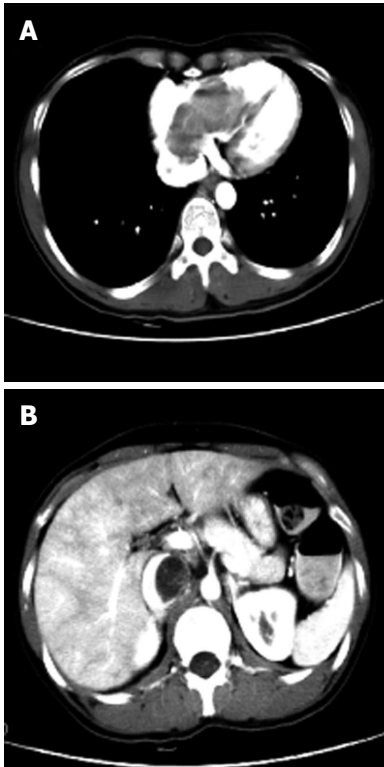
Preoperative chest and abdominal computed tomography. A: Axial image demonstrates a lobulated mass within the right atrium and ventricle; B: Axial image shows a tumor in the inferior vena cava and resulting lumen stenosis.
